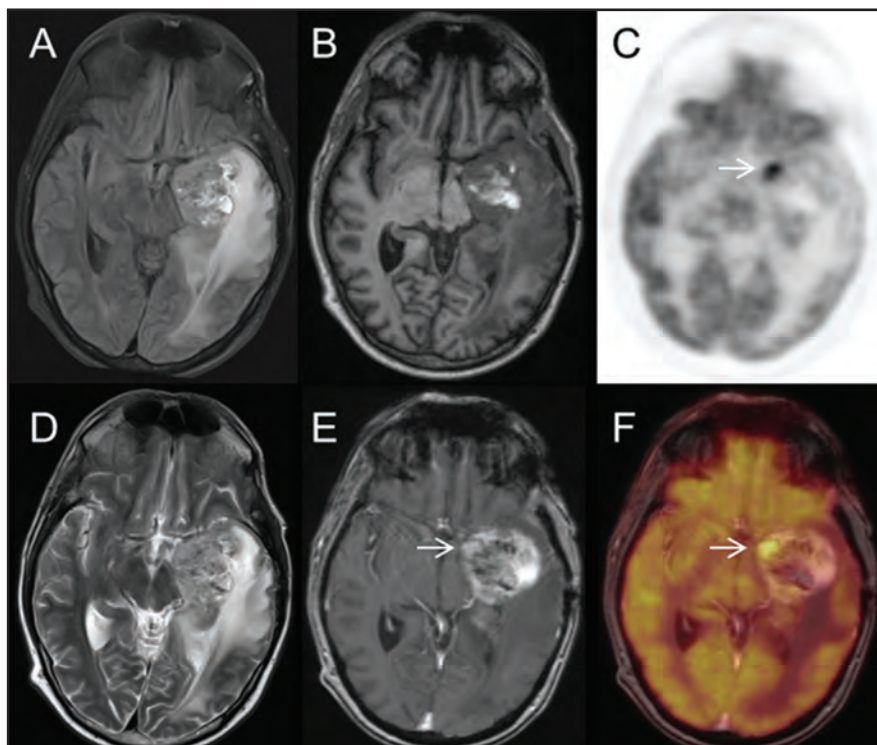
Left temporal lobe primitive neuroectodermal tumor (PNET), recurrent after resection and radiation to the bed. Arrows show focal region of FDG uptake, which was found to be recurrent tumor and radiation necrosis. A = T2 FLAIR, B = T1 MPRAGE precontrast, C = FDG-PET, D = TSE T2, E = T1 postcontrast, F = fused FDG-PET and T1 postcontrast images.
